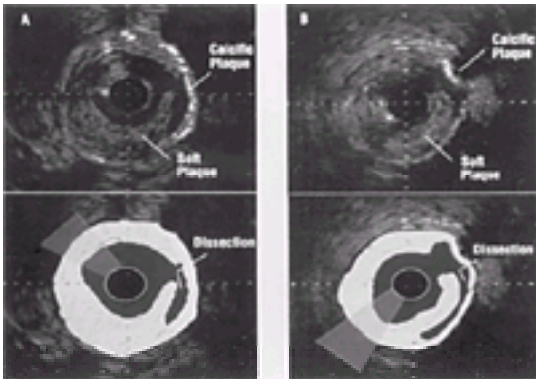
Intravascular ultrasonograms of (A) calcific plaque and (B) soft plaque with associated dissection.
